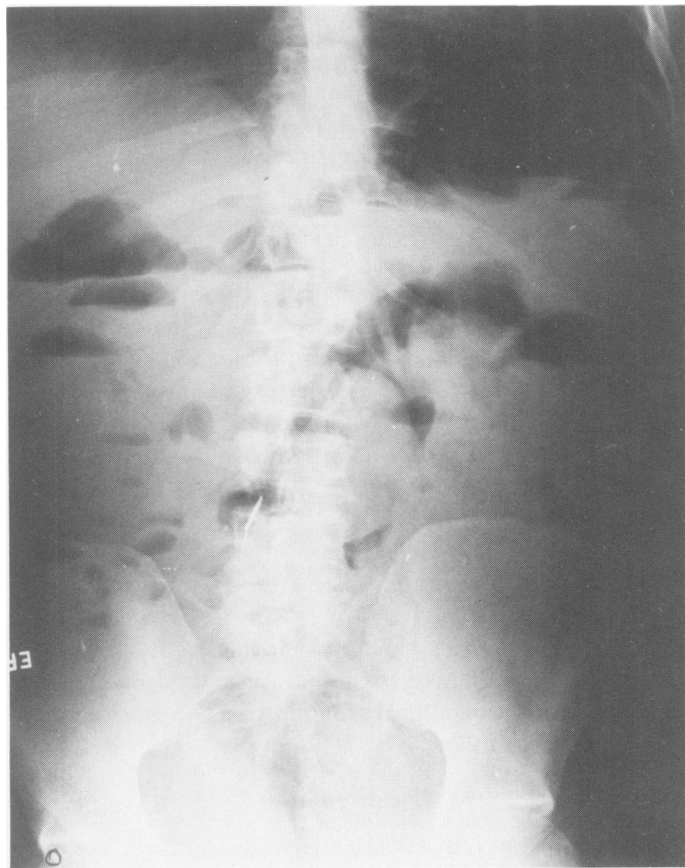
(J.C.) Upright roentgenogram of the abdomen taken on admission to hospital and showing multiple air-fluid levels.
